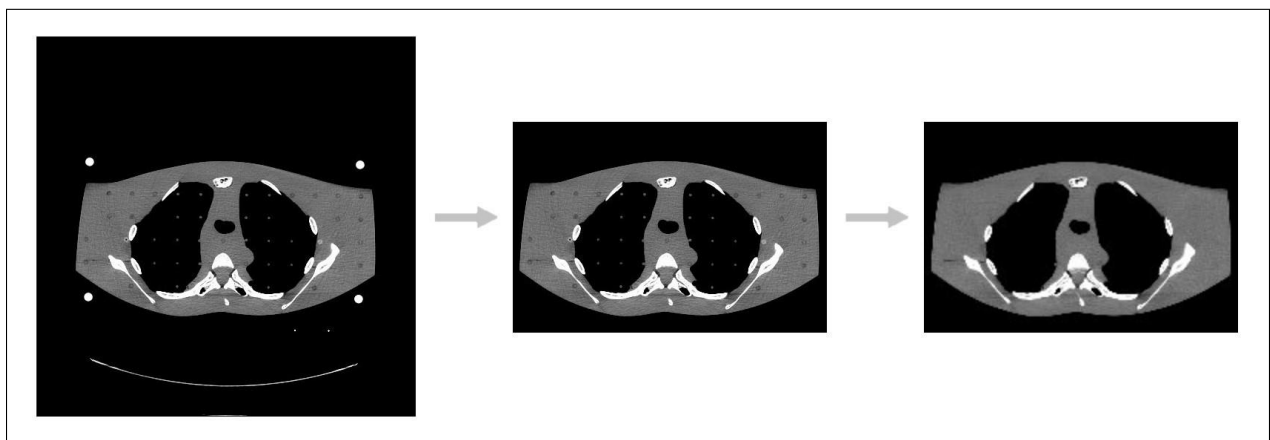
An example CT slice taken through the image processing procedure. Left: the original slice. Middle: the slice after removal of the couch and excess air. Right: the slice after HU value adjustments to remove non-anatomical discontinuities.
